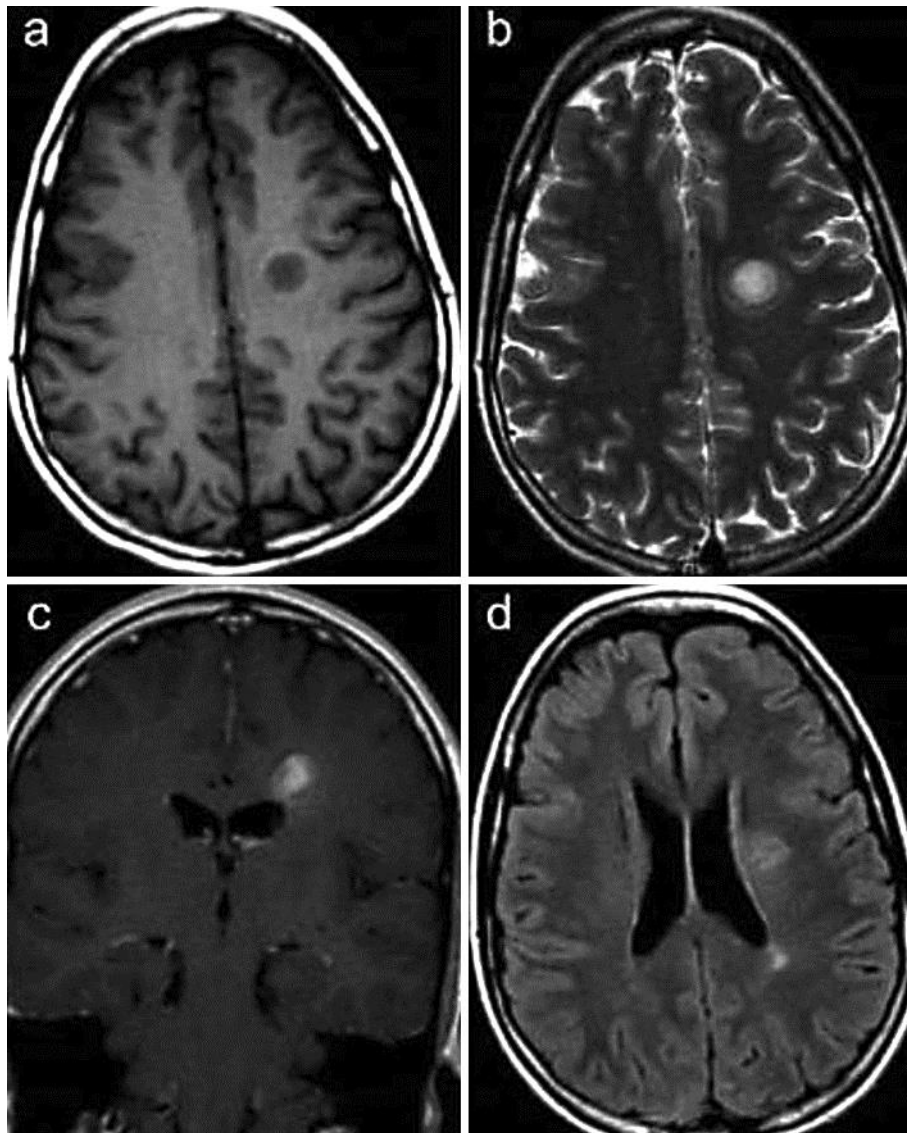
a Axial T1W MRI (baseline MRI) shows a 2 cm sized well-circumscribed hypointense lesion in the left centrum semiovale. b Corresponding axial T2W MRI shows ill-defined concentric bands within the lesion. There is minimal peri-lesional oedema. c Corresponding contrast-enhanced coronal T1W MRI shows concentric enhancement within the lesion, which is pathognomonic of BCS. d Corresponding axial FLAIR image shows the Balo lesion along with a simultaneous small ovoid hyperintense lesion in the left peri-trigonal white matter. These findings indicate associated MS.
